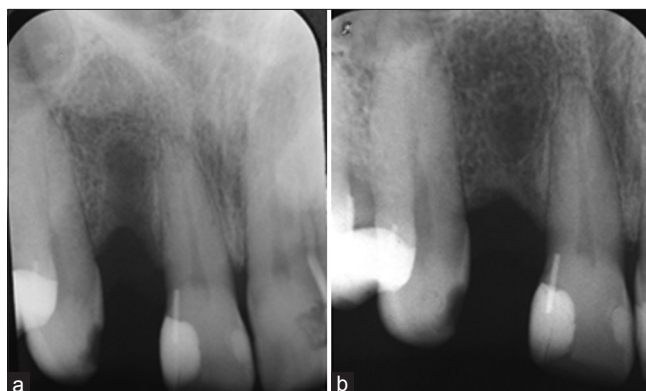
Periapical radiograph: (a) Two months after extraction, (b) immediately before implant placement
